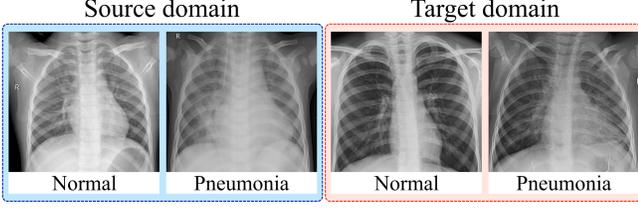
Images of normal and pneumonia chest X-ray images from source and target domain datasets used in this work.
